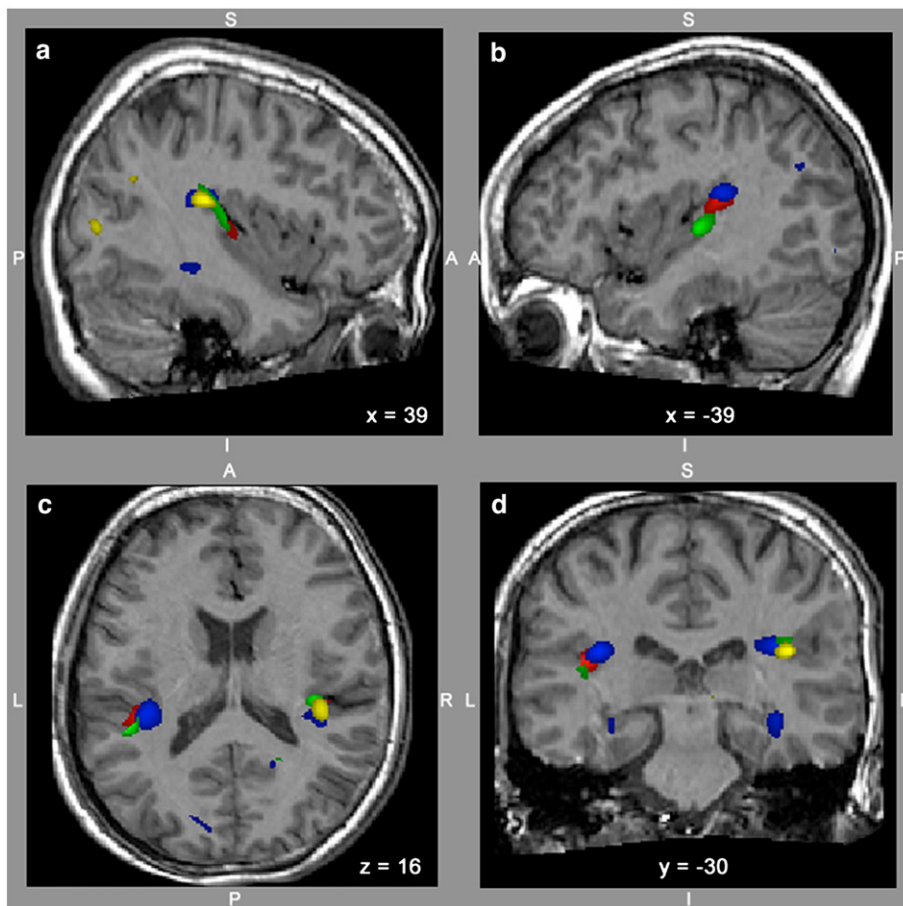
Clusters of significant increased fractional anisotropy (FA) (as shown in Fig. 1) and increased white matter (WM) volumes (as shown in Fig. 2) in the brain of the synaesthete E.S. compared with 20 normal control subjects (FA in green; WM volumes in yellow) and 17 professional musicians (FA in red; WM volumes in blue). Shown are a right (a) and a left sagittal plane (b) through the perisylvian cortex and the insular region as well as the corresponding axial (c) and coronal (d) planes. The z-score maps are superimposed on the structural MR image of the synaesthete E.S.
